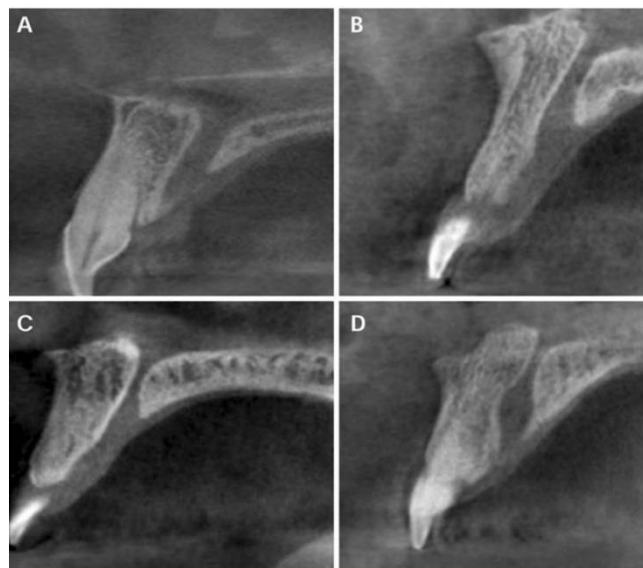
The classification of NPC based on sagittal sections of CBCT images, A: cylindrical B: banana C: hourglass D: funnel
